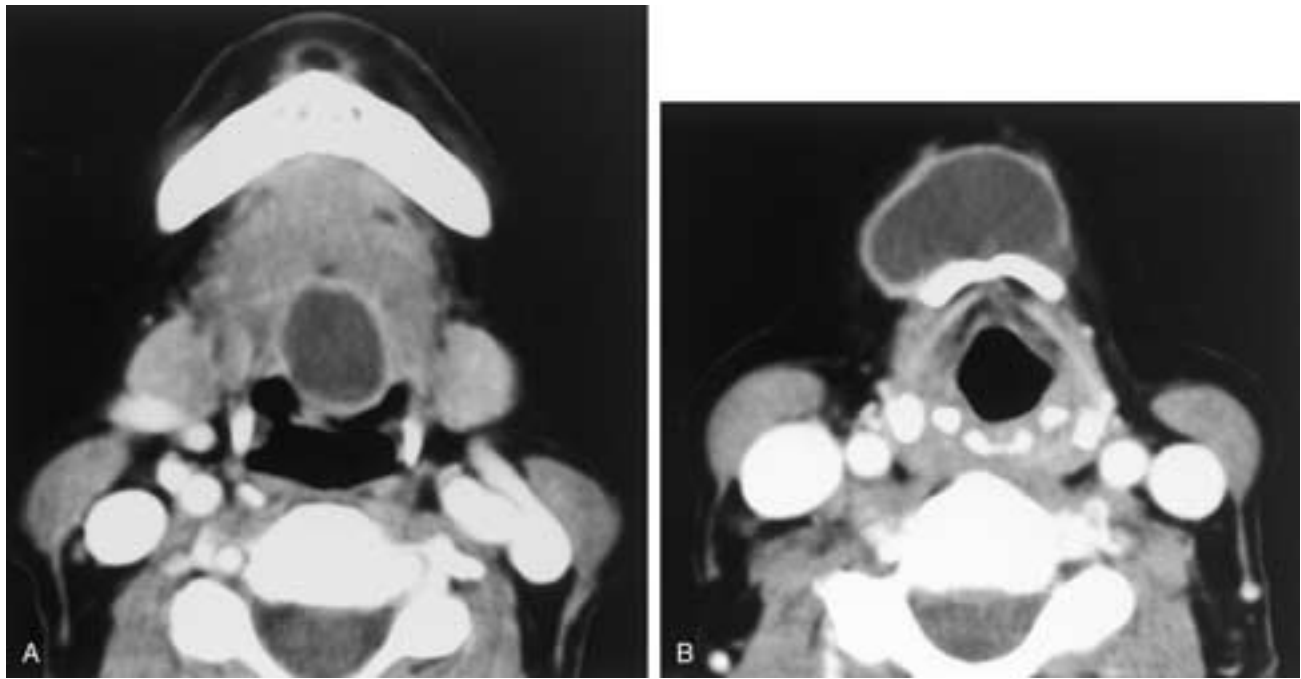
Thyroglossal duct cyst. A and B, Contrast-enhanced axial CT scans reveal a well-circumscribed, rim-enhancing cystic mass along the entire path of the thyroglossal duct from the foramen cecum (A) into the infrahyoid neck.
